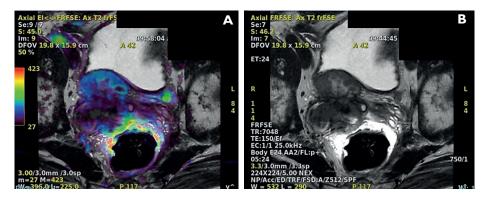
3D-CSI 1.5 magnetic resonance imaging: coloured parametric maps (A) superimposed to T2-weighted image (B).
